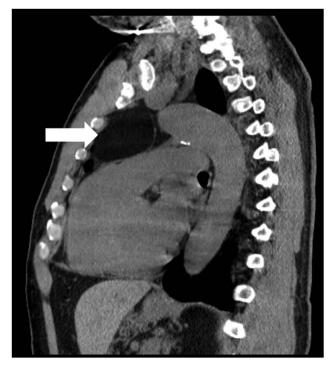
Thoracic computed tomography without contrast, sagittal view. The arrow identifies a well-encapsulated large $7.5 \times 5 \times 6$ cm lipomatous anterosuperior mediastinal mass adjacent to the left phrenic nerve.
